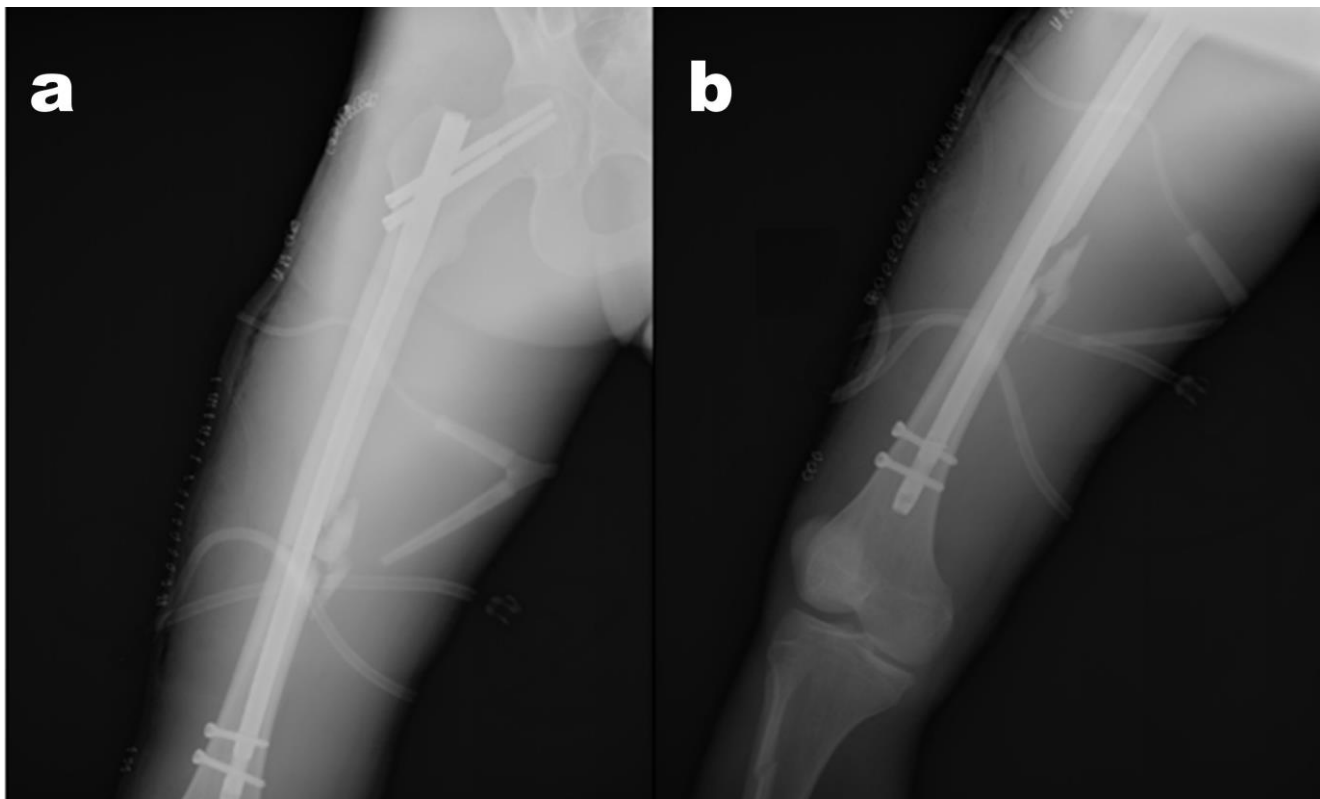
a, b) Postoperative femur radiographs of the patient taken before the traffic accident.
